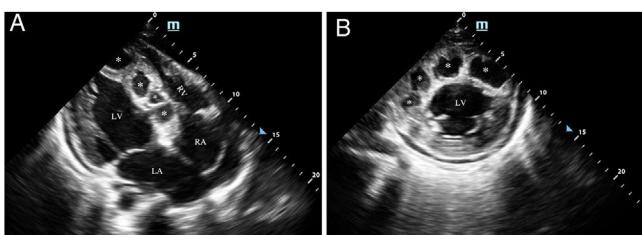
(A) Two-dimensional (2D) transthoracic echocardiography showing multiple hydatid cysts in the interventricular septum in 4-chamber view; (B) 2D transthoracic echocardiography showing multiple hydatid cysts in the interventricular septum in left ventricular short-axis view.
